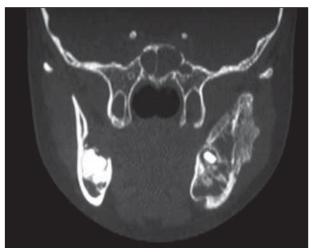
Coronal computed tomographic image demonstrating hemimandibular involvement by an isolated neuroblastoma.
